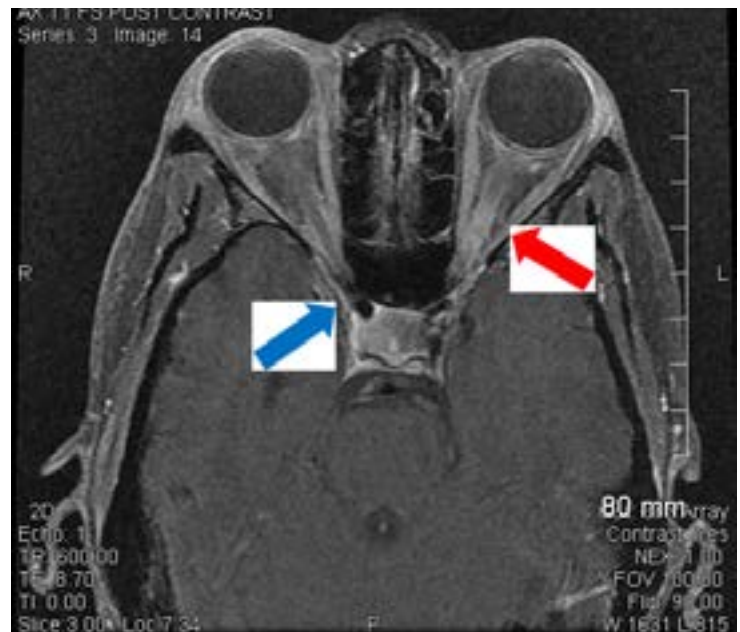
MRI of the orbits obtained at the patient's hospital visit (Visit 1). Red arrow: faint abnormal enhancement involving the posterior intraorbital portion of the left optic nerve extending posteriorly to involve the pre-chiasm. Blue arrow: very faint abnormal enhancement of the prechiasmatic portion of the right optic nerve.
